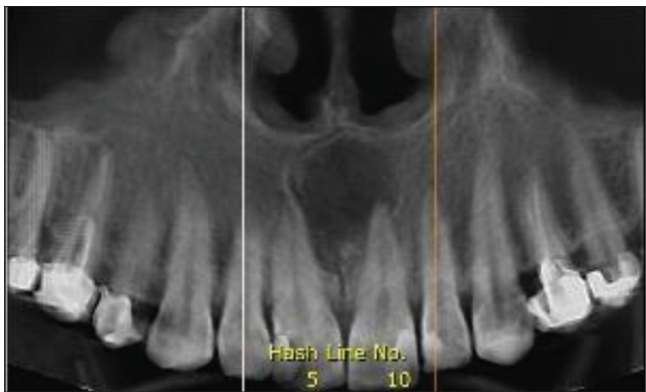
Panoramic reconstructed cone-beam computed radiographic image shows incisive canal cyst; a well-defined radiolucent, anterior unilocular inter-radicular lesion in midline of maxilla
